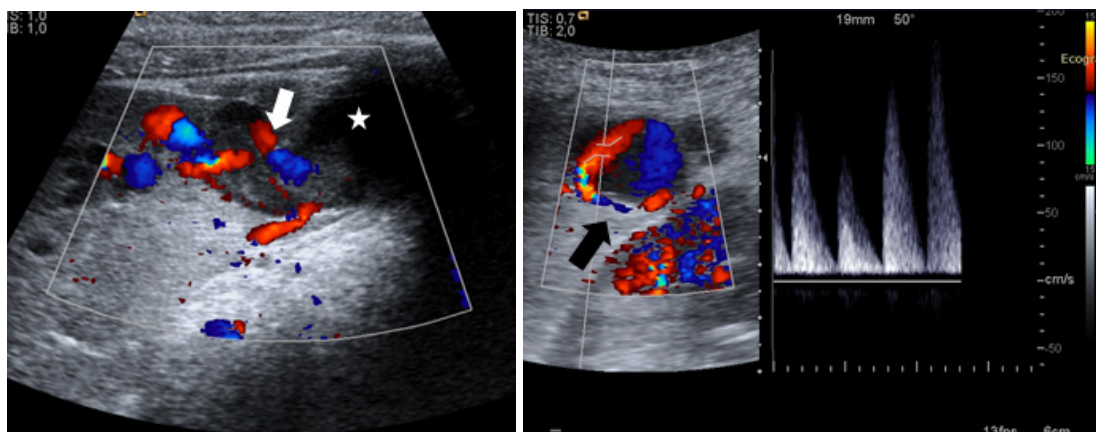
Doppler-US. Subcapsular splenic hematoma (star) and areas of arterial flow in its vicinity (arrow, left) with yin-yang sign (arrow, right), suggesting pseudoaneurysm.
